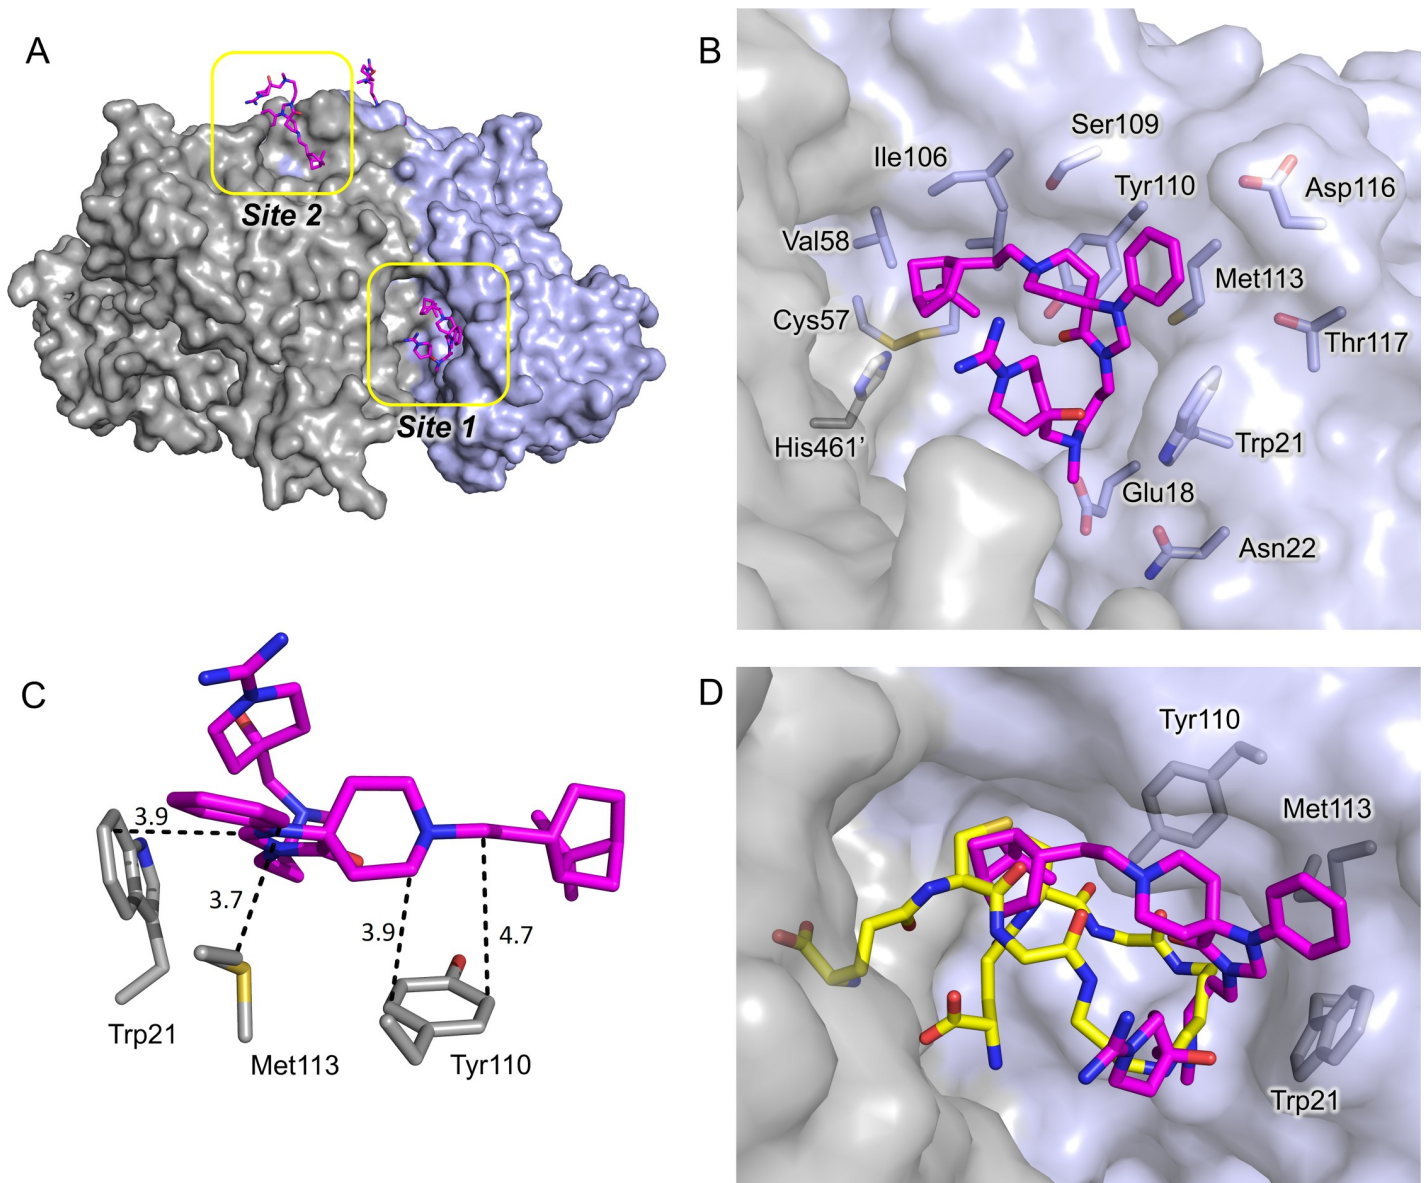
X-ray structure of 1-TR. (A) Overall fold of TR in complex with compound 1. The accessible solvent areas of the two-fold symmetry related monomers are indicated in grey and blue respectively; the sites 1 and 2 are indicated by yellow boxes and compound 1 is represented as magenta sticks. (B) Binding site 1: the residues lining the binding site and the catalytic residues are represented as sticks. Compound 1 carbon atoms are colored in magenta and the protein residues carbon atoms in grey. The accessible solvent area of the cavity is colored grey. (C) Detail of the compound 1-*Tb*TR interaction. Compound 1, Trp21, Met113 and Tyr110 are represented as sticks. (D) Superposition of TR-1 and *Tb*TR in complex with TS₂ (pdb: 2wow). Carbon atoms of compound 1 are colored in magenta whereas the carbon atoms of TS₂ are colored yellow. Trp21, Met113 and Tyr110 are indicated. The solvent accessible area is represented and colored in grey. The pictures were obtained using PyMOL (The PyMOL Molecular Graphics System, Version 2.0 Schrödinger, LLC).
